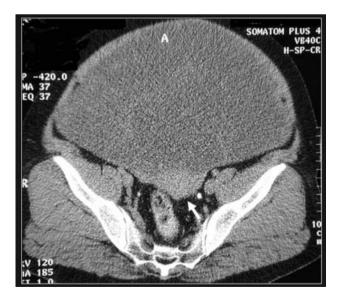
CT image shows a large $(35 \times 30 \times 15 \text{ cm})$, homogeneous, low-density abdominopelvic tumor. The uterine body is visualized posterior to the tumor (white arrow). Even retrospectively, no fat or mucin areas were identified.
